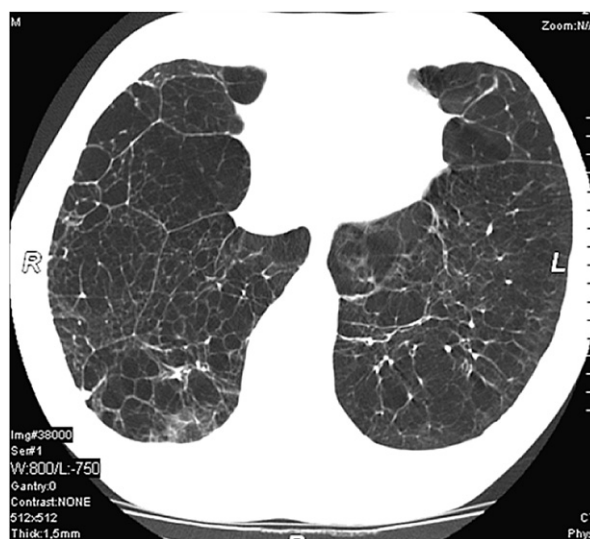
Computed tomography of the thorax of a patient with severe emphysema. Large bullae in both lungs and severe panlobular emphysema, rarefaction of pulmonary parenchyma and pulmonary vessels.
